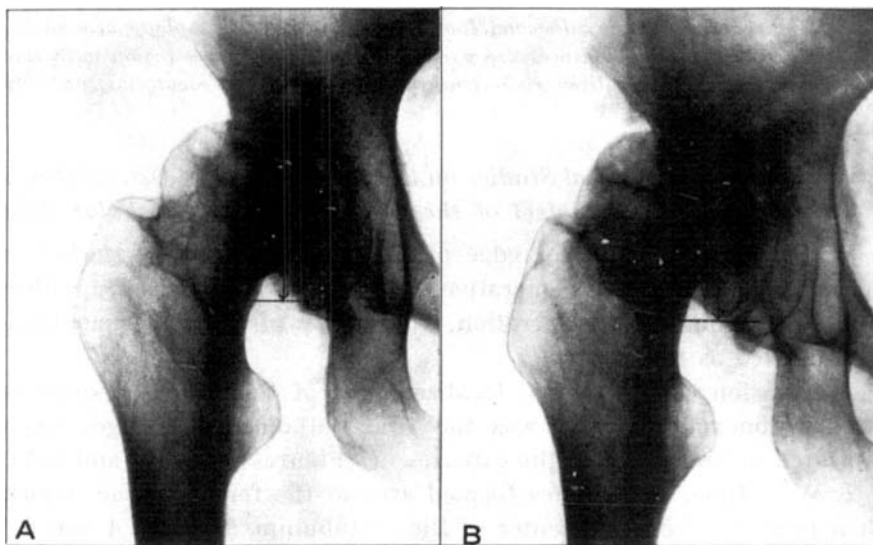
Roentgenograms showing rapid upward migration of the femoral head in the dysplastic hip with osteoarthritis. Figure 7-A in November, 1964, Figure 7-B May, 1965. The upward migration of the femoral head was accompanied by an enlargement of the medial osteophyte, indicated by arrows.
